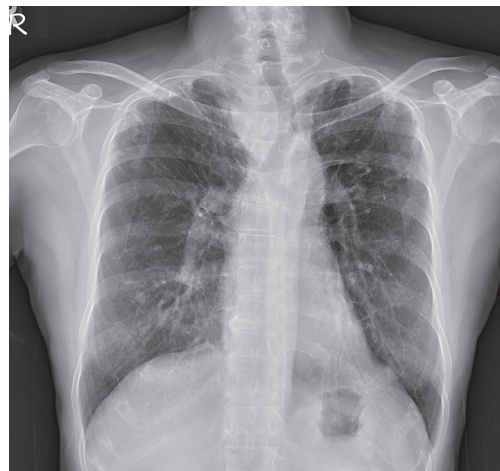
Chest radiograph showed a bulging mass in right superior mediastinum causing left-sided tracheal deviation.
